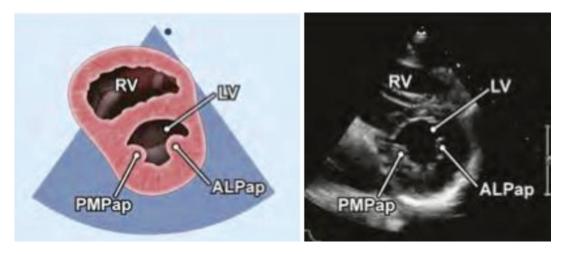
Parasternal short axis. (Reprinted from Mitchell et al. [11]. With permission from Elsevier)
